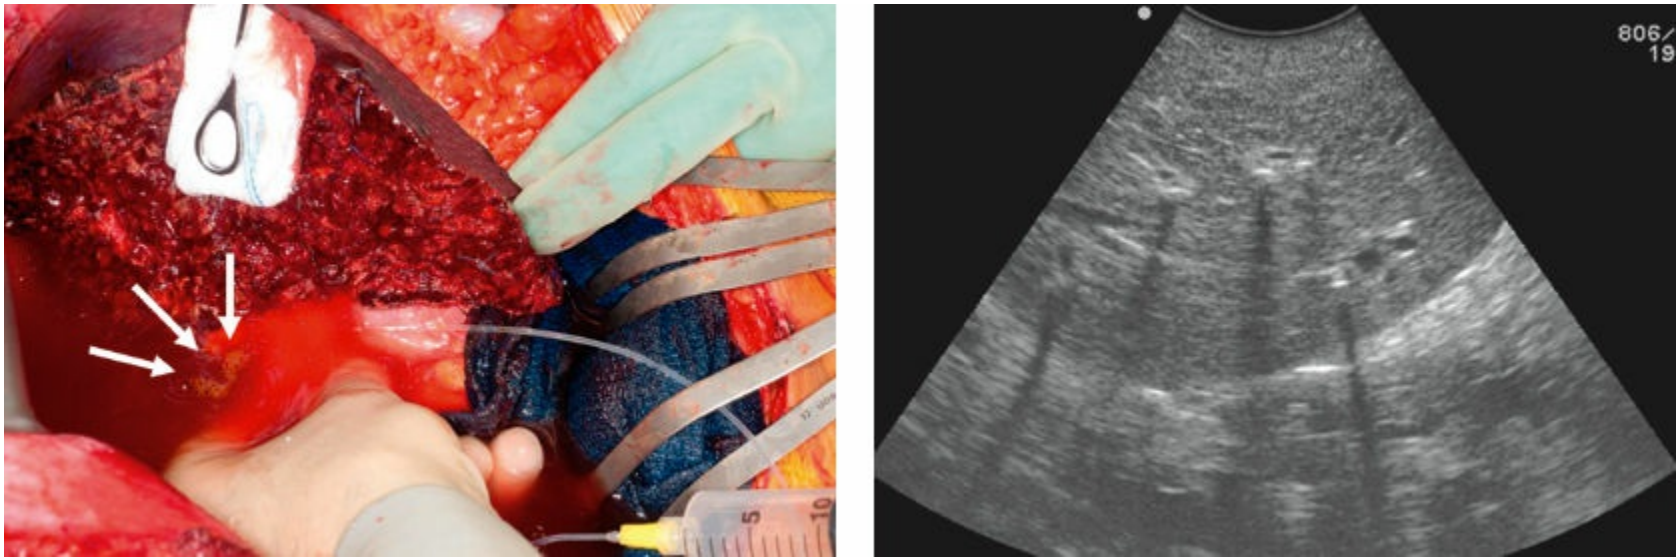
Air leak test for detection of bile leak. Left: With injection of air into the biliary tract, the point of bile leak can be sensitively detected as an air leak point (arrows). Right: Patency of the bile duct can be confirmed as pneumobilia on ultrasound image. (Adapted from Zimmitti G. Systematic use of an intraoperative air leak test at the time of major liver resection reduces the rate of postoperative biliary complications. *J Am Coll Surg* 217;1028–1037, with permission.)
